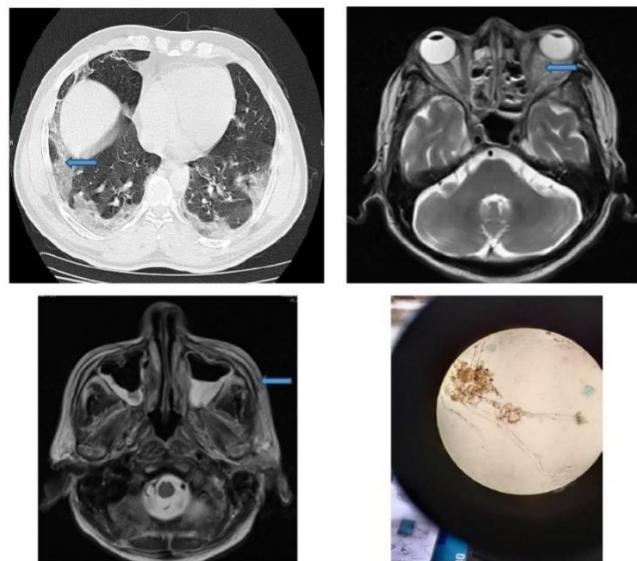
A 60 years old male, CT chest: diffuse bilateral ggo (subpleural), MRI: Mucosal thickening with T2 low signal areas noted in right superior turbinate of nasal cavity and moderate mucosal thickening with T2 low signal areas noted in B/L ethmoid, maxillary, and left frontal sinuses. Ill defined enhancing soft tissue with edema noted in inferomedial extraconal space of B/L orbit, more in left orbit with thickening of bilateral medial and inferior recti. KOH mount: Fungal elements are seen clearly.
